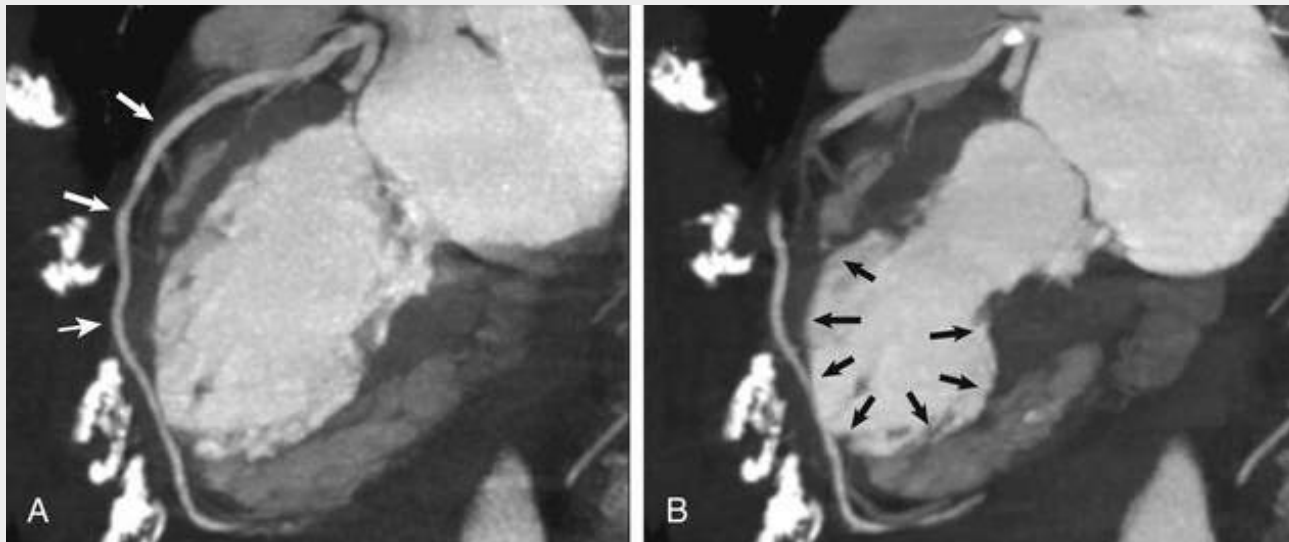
Cardiac MRI in a patient with Takotsubo cardiomyopathy. A, Cardiac MRI (diastolic frame) demonstrating a patent left anterior descending artery (*arrows*). B, Classic apical ballooning (*arrows*) of the left ventricle (systolic frame) in the same patient as in A. (From Sanz J: Evolving diagnostic and prognostic imaging of the various cardiomyopathies. *Ann N Y Acad Sci* 2012;1254:123.)
